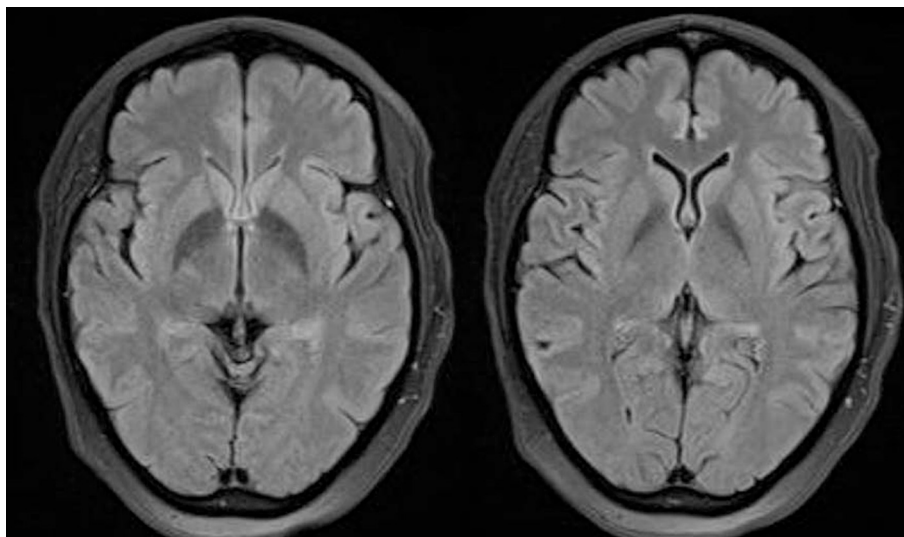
Brain MRI showed a subtle increase in the signal on FLAIR images at bilateral hippocampi and insula that was correlating with postictal changes.
